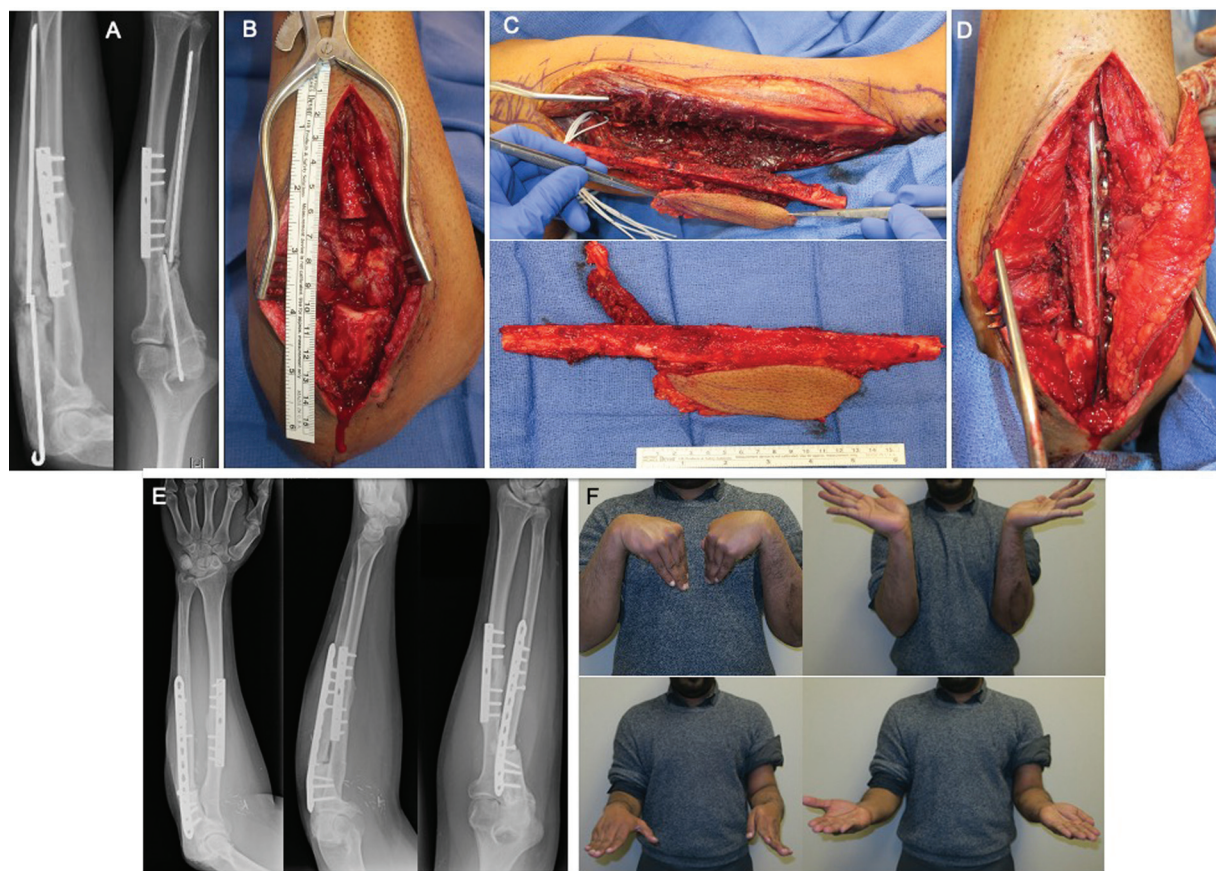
Case example of a man with ulnar nonunion having undergone 13 previous surgeries now successfully treated with a free, vascularized fibular graft. A) Depicts his lateral and anterior-posterior X-ray prior to his fibular graft reconstruction. B) Depicts his forearm recipient surgical site. The donor site and free vascularized fibular osteocutaneous graft are depicted in C) with the graft implanted in D). E) Depicts X-rays at 8-month post-op with a successfully healed union, and the patient's corresponding range of motion in F).
